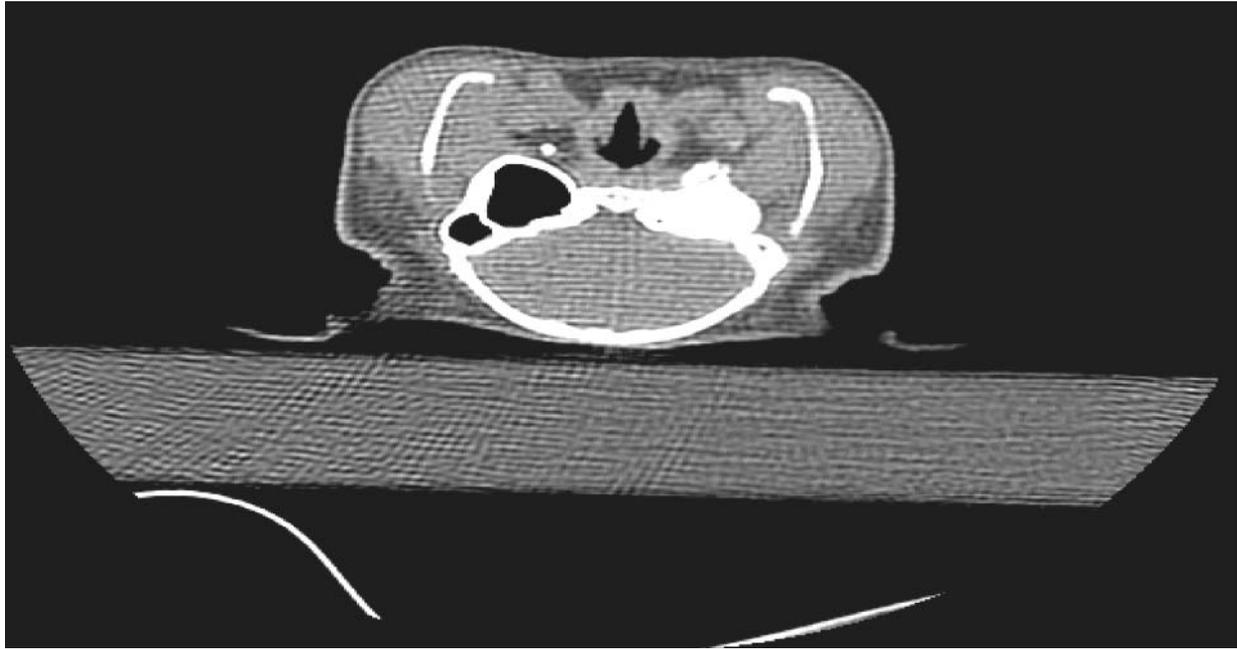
The hyperintense occlusion of bulla with bioactive glass seen on axial CT scan at five months after obliteration.
